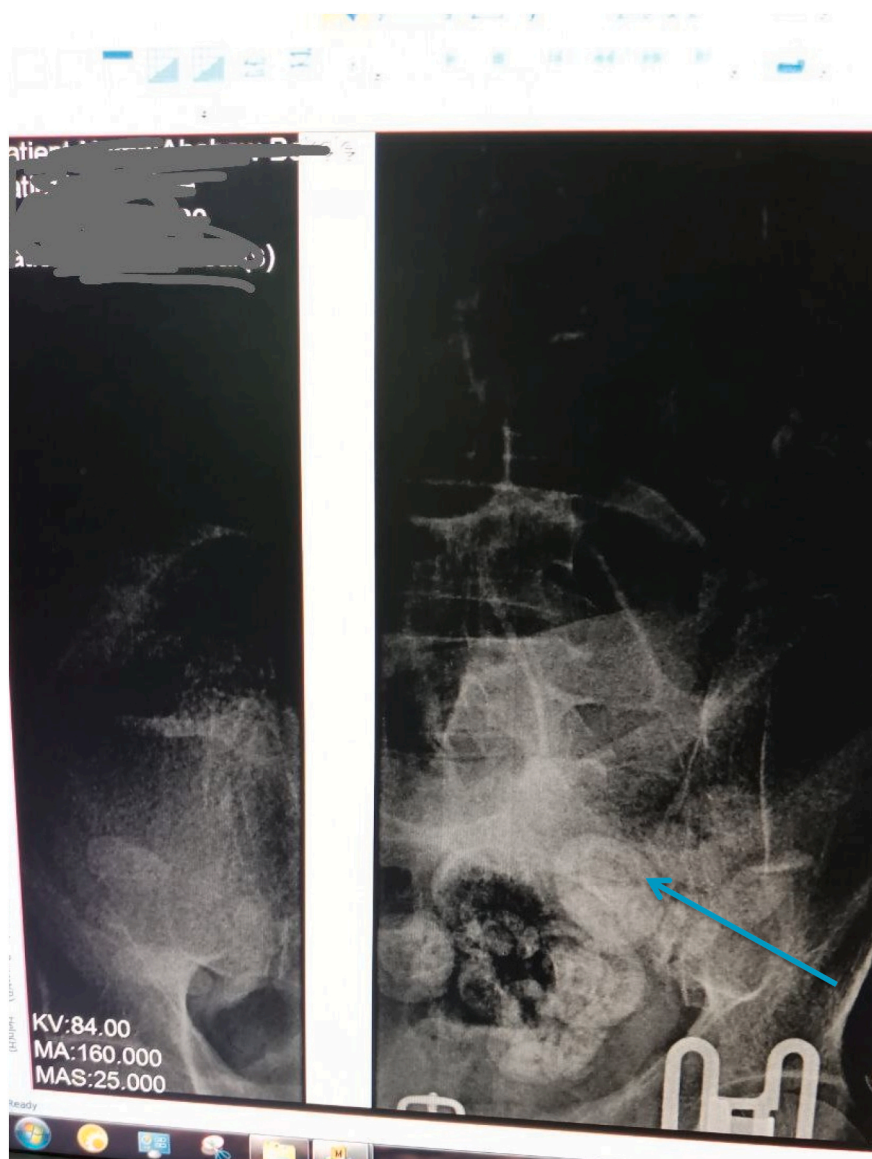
Enteroliths at the upper rectum on follow-up x-ray.
